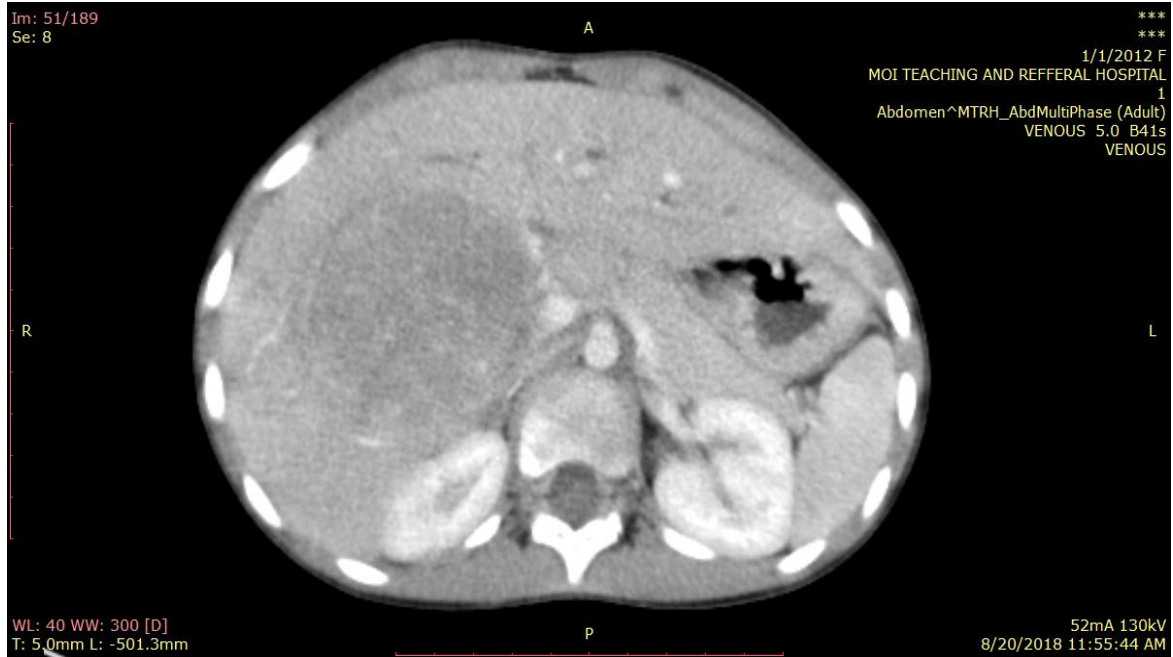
to 9 below present selected CT scan images of hepatic masses included in the study
